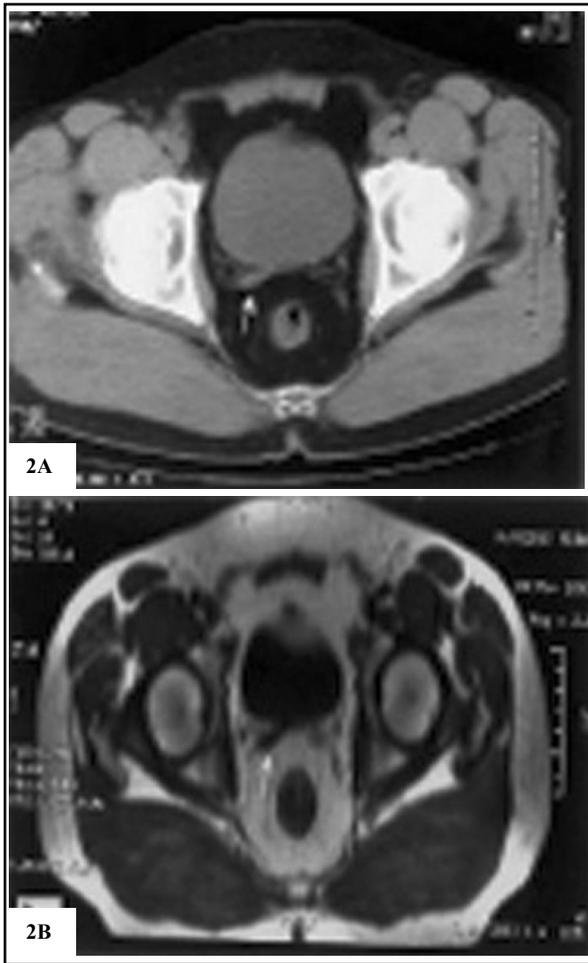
(A,B): CT and MRI demonstrates absence of left seminal vesicle and right hypoplastic seminal vesicle with similar signal intensity of muscle or bladder.
